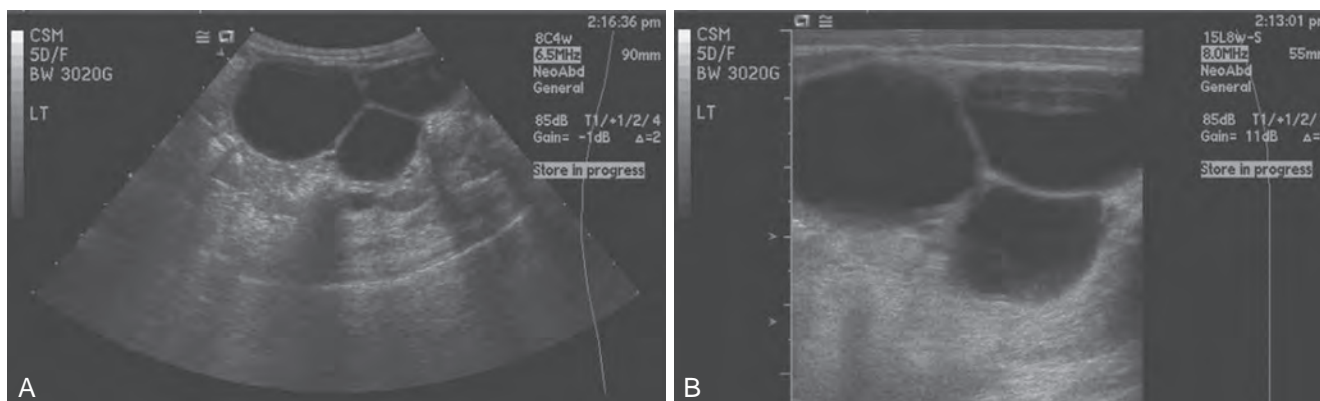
A and B, Renal ultrasonogram of large left multicystic dysplastic kidney. There are multiple large cysts. No definite renal cortex is seen.
